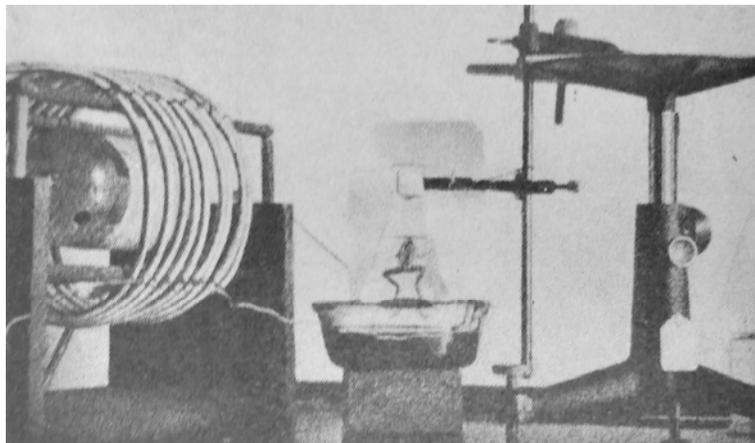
The coil and reaction chamber used by Wood and Loomis in their studies into the physical and biological effects of high-intensity ultrasound. [42]
